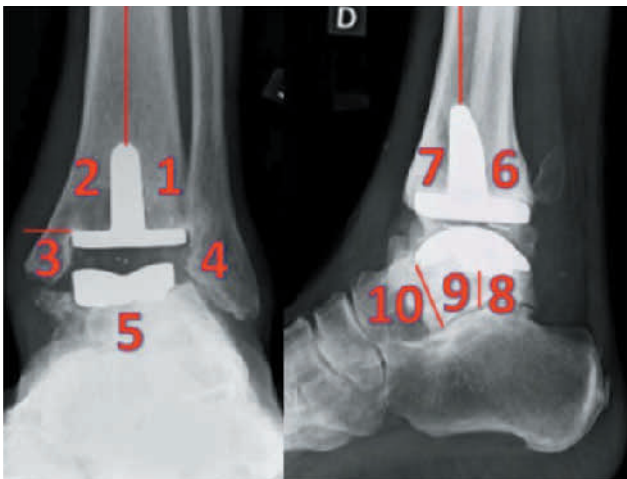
Protocol for X-ray analysis according to Besse et al.
